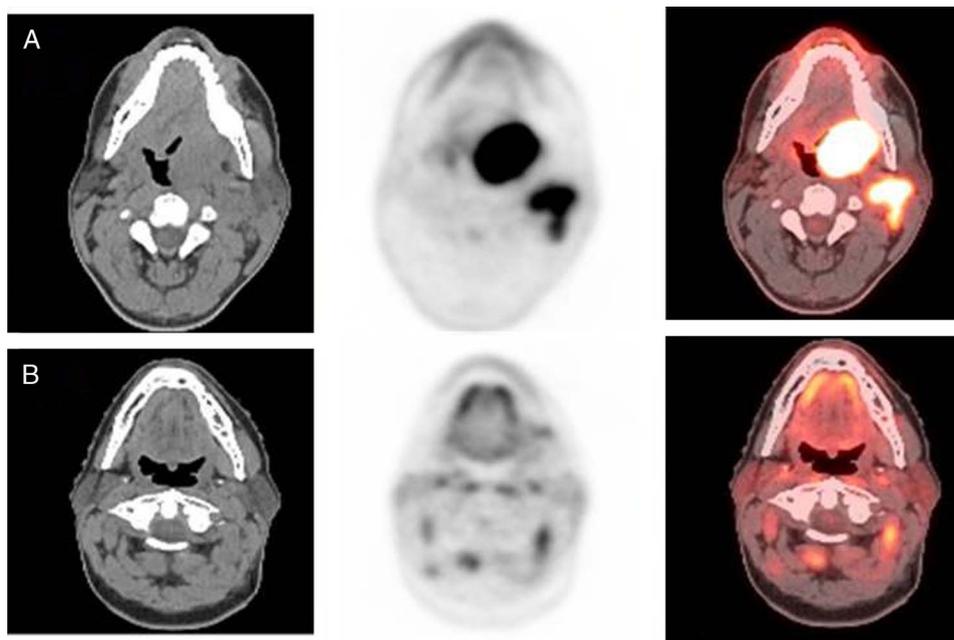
Therapy response—complete metabolic response. A 56-year-old man, T2N1M0 left tonsil tumor with metastatic level II lymph nodes. Axial CT, PET, and fused images showed primary tumor and metastatic lymph nodes (A). He received concurrent CRT and 3 months posttherapy ¹⁸F-FDG PET/CT demonstrated complete response (B).
